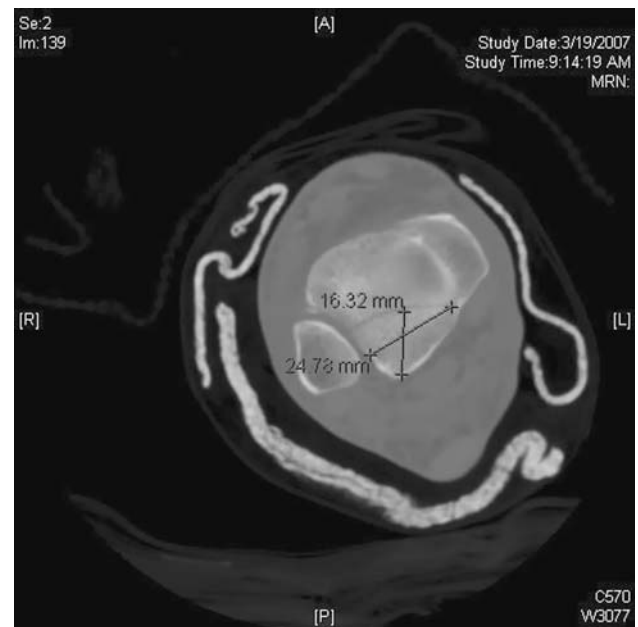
An axial section of the CT scan shows the measurements of the posterior malleolus fracture fragment.
